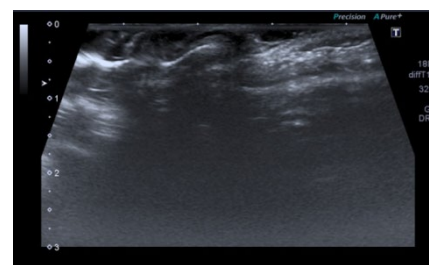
The control ultrasound of the postoperative area 7 months later. The hypoechoic formation (cicatricial tissue) of 10x3mm is determined. The surrounding tissue without visible changes
